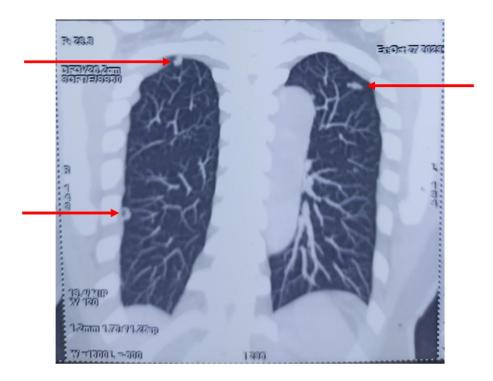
CT image in coronal section of the lung window with demonstration of bilateral nodular lesions of variable size, including two on the right and one on the left (arrows in red) persisting after chemotherapy.
